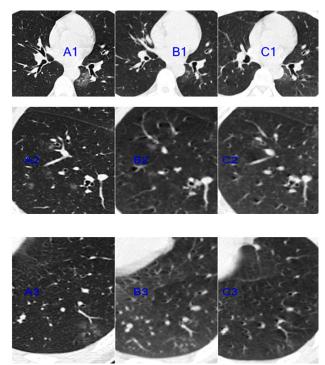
A local 33-year-old man. Figure (A1-3) shows a chest computed tomography (CT) scan from another hospital 2 days after onset; multiple GGOs are noted in both lungs. Figure (B1-3) shows the chest CT re-examination scan obtained in our hospital 2 days after anti-microbial therapy with moxifloxacin; some lesions are absorbed. Figure (C1-3) shows a chest CT re-examination scan in our hospital 5 days after anti-microbial therapy with moxifloxacin; most of the lesions are absorbed. The patient was diagnosed with bacterial pneumonia.
